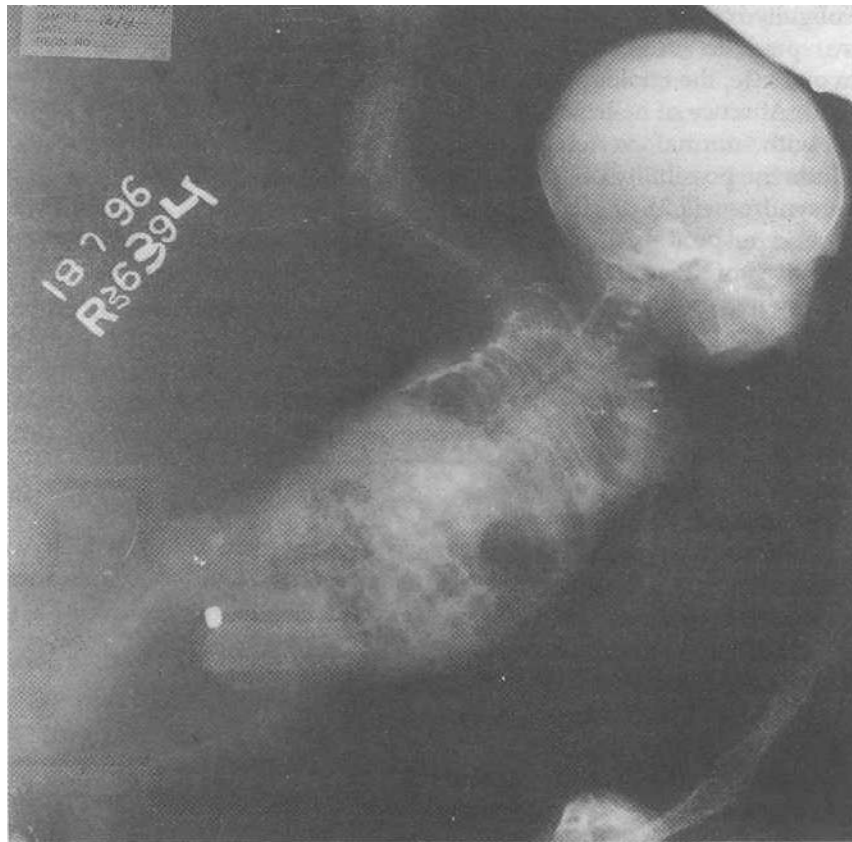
X-ray showing micrognathia, hypoplastic left humerus, bilateral femoral hypoplasia, variable intercostal spaces with crowding and fusion of ribs.
